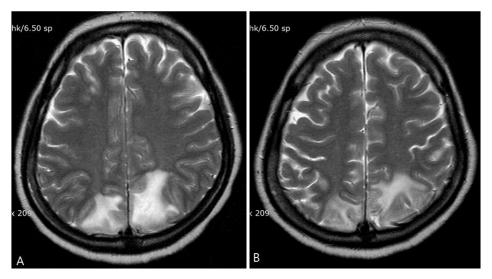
(A) Axial T2-weighted magnetic resonance imaging (MRI) showing an area of high signal intensity in the bilateral white matter of the posterior parieto-occipital area. (B) Six weeks later, axial T2-weighted MRI showing significant improvement after cyclosporine withdrawal.
